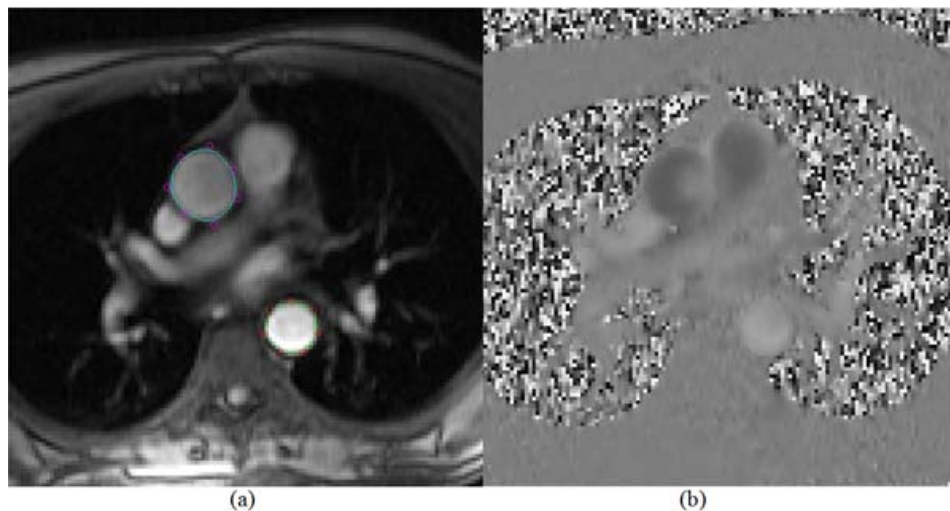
Output of PC MRI of transected aorta. Magnitude (a) and corresponding phase (b) images.
